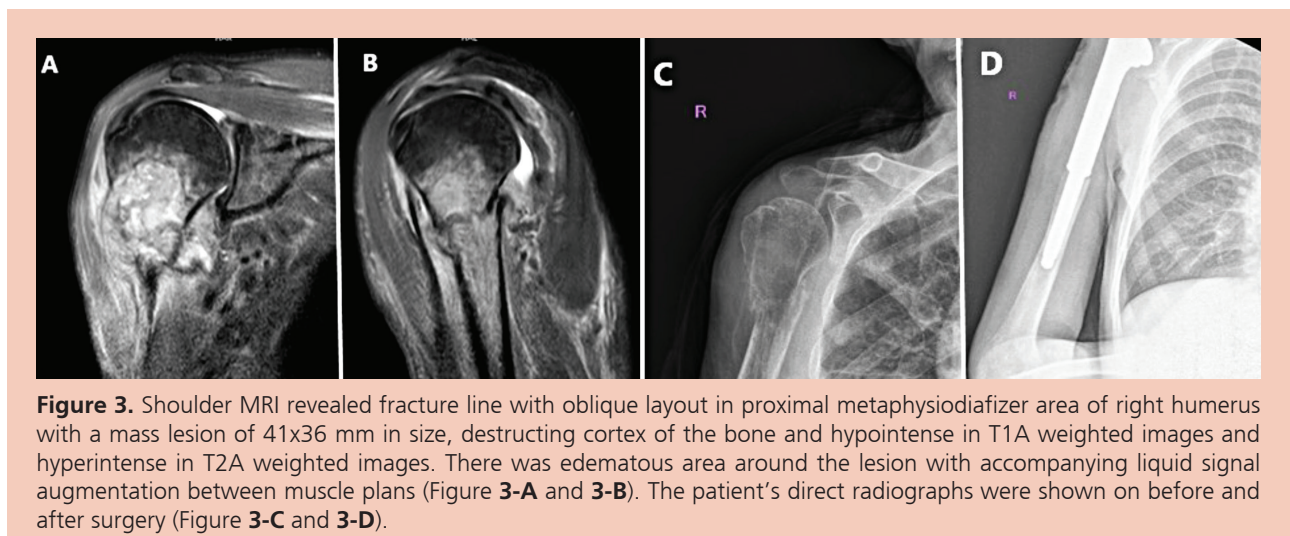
Shoulder MRI revealed fracture line with oblique layout in proximal metaphysiodiafizer area of right humerus with a mass lesion of 41x36 mm in size, destructing cortex of the bone and hypointense in T1A weighted images and hyperintense in T2A weighted images. There was edematous area around the lesion with accompanying liquid signal augmentation between muscle plans (Figure 3-A and 3-B). The patient's direct radiographs were shown on before and after surgery (Figure 3-C and 3-D).
